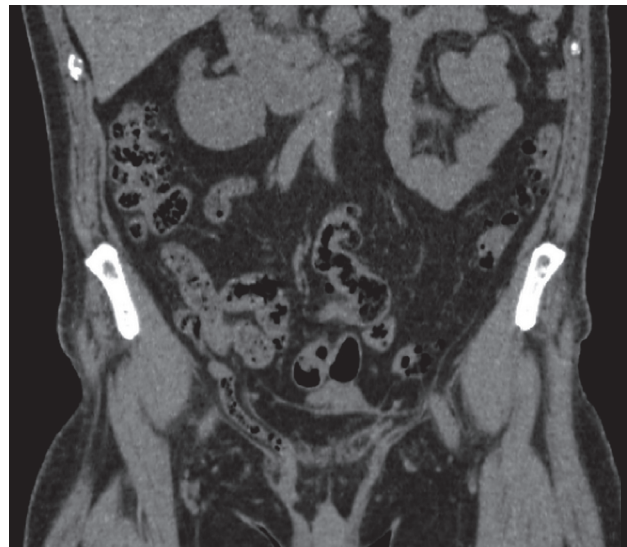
Amyand's hernia: abdominal and pelvic computed tomography, coronal plan, showing the appendix extending into the right inguinal canal without signs of inflammation, infection or perforation
